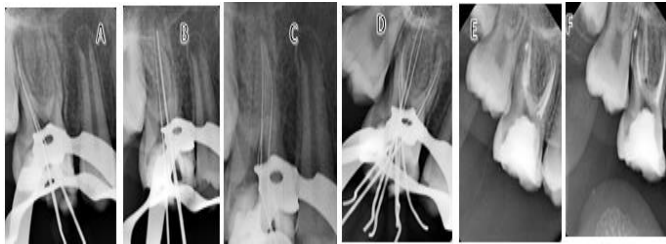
A: Working length radiograph for the distobuccal canals, B: Working length radiograph for the palatal canals, C: Working length radiograph for the mesiobuccal canals, D: Working length radiograph for all canals, E: Angled postoperative radiograph, F: Straight postoperative radiograph.
